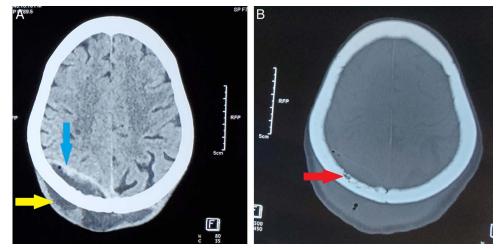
(A) Computed tomography of the head: (A) (brain window) showing subgaleal (yellow arrow) and epidural (blue); (B) (bone window) of the same scan revealed lytic areas (red arrow) in the right parietal and occipital bones, which is indicative of osteomyelitis.
